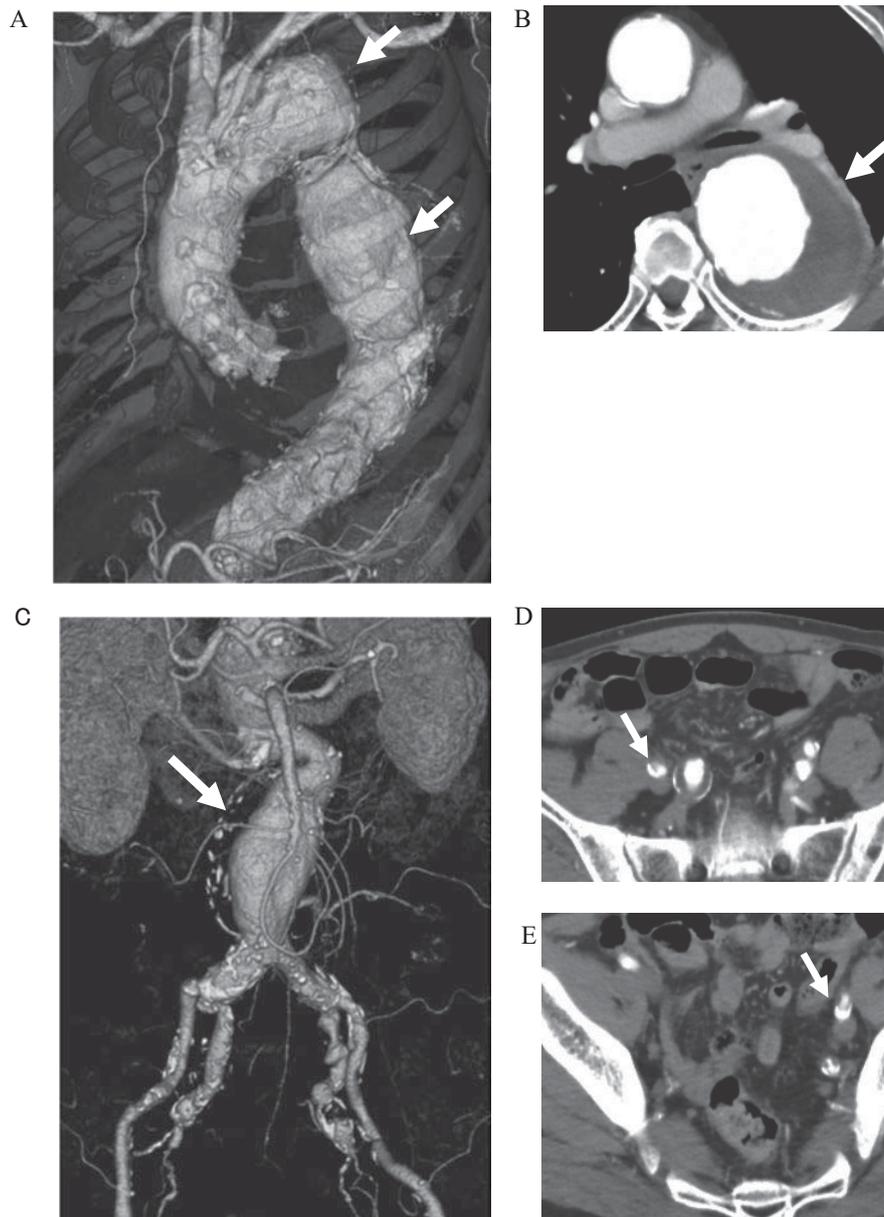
Contrast CT findings
